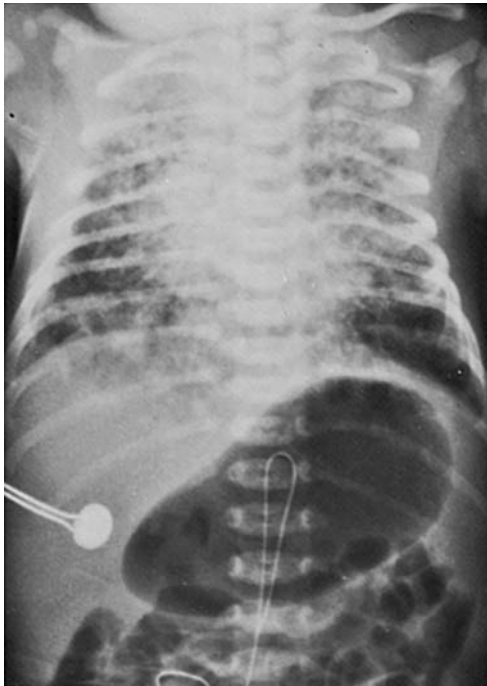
Chest x-ray film of infant with meconium aspiration. Note diffuse infiltrates.
